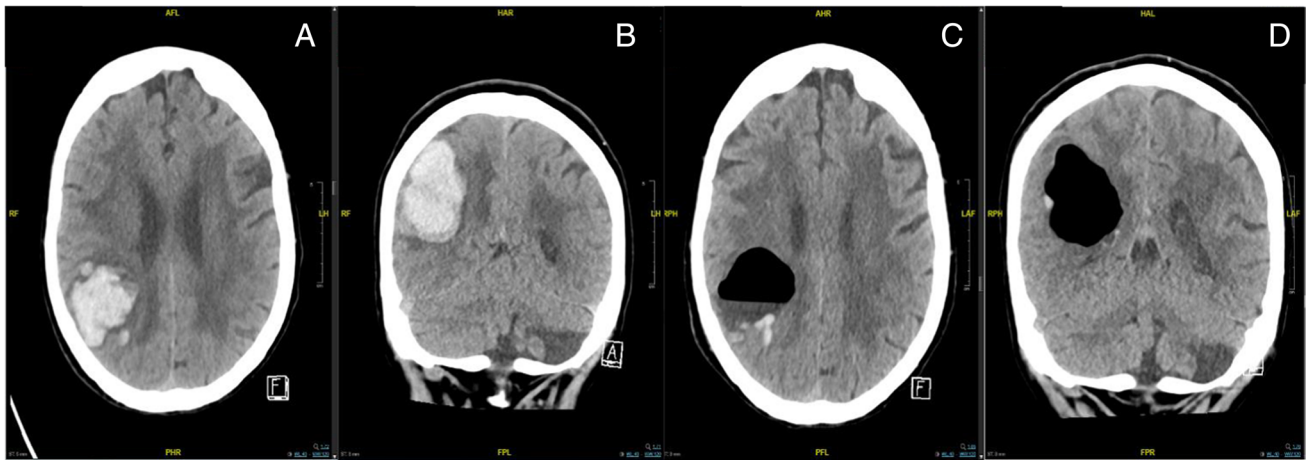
Preoperative CT scan of a lobar SSICH in a axial and b coronar axis. Postoperative CT scan of the same hematoma with minimal residual hematoma in c axial and d coronar axis
